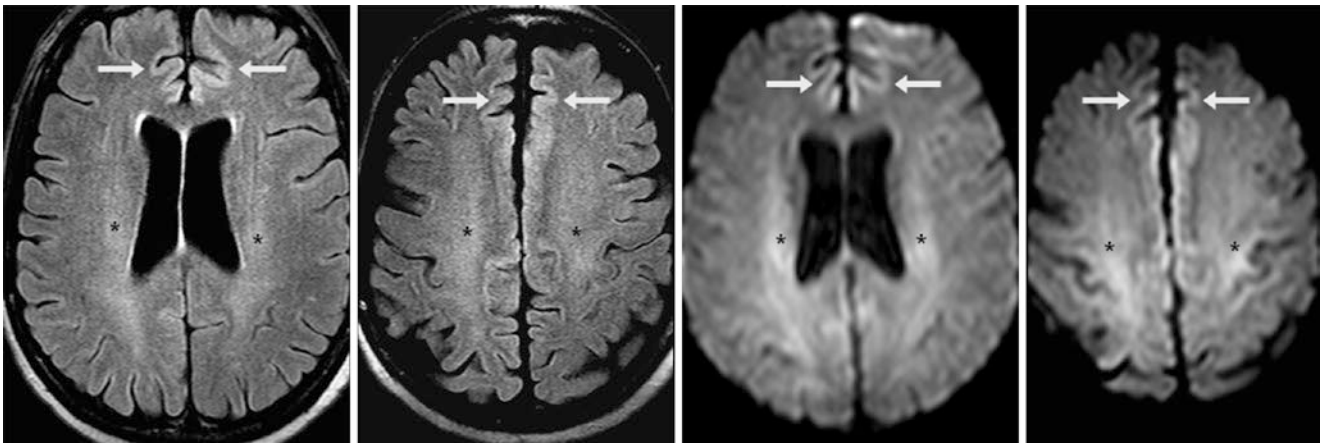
A 60-year-old with altered mental status had symptoms that resolved within 1 day. A 3 T MRI with FLAIR (*left and left middle*) and DWI (*right and right middle*) showed normal, mild hyperintensity
